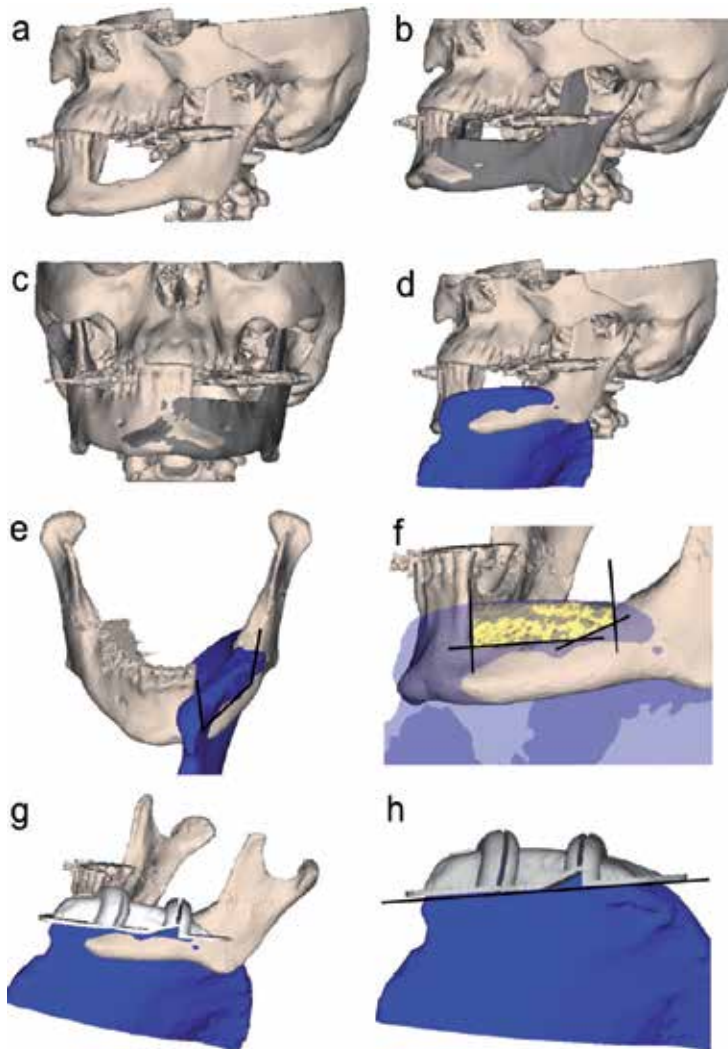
Exemplary operational sequence of virtual osseous reconstruction with CAD/CAM technique. (a) Initial findings in 3-D CT, (b) and (c) Mirroring the unaffected side for virtual reconstruction, (d) Selecting a proper harvesting site by precisely superimposing the virtually reconstructed side, (e) and (f) Virtually harvesting, trimming and inseting of the osseous transplant, (g) and (h) Designing patient-specific cutting guides for 3-D printing.
